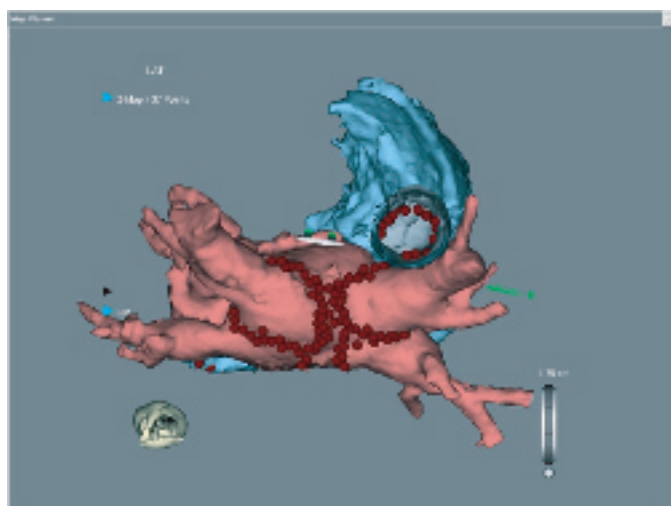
Image integration of CT with electroanatomical map in AF ablation.
